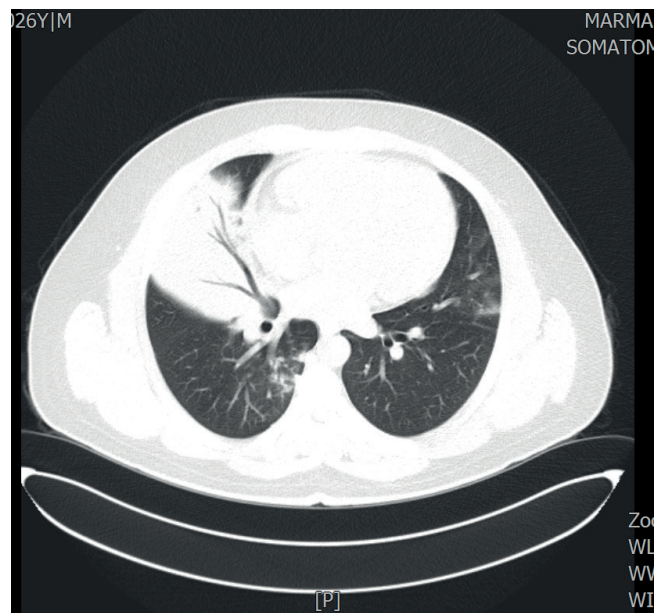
Lobar consolidation due to adenovirus pneumonia on thorax CT
